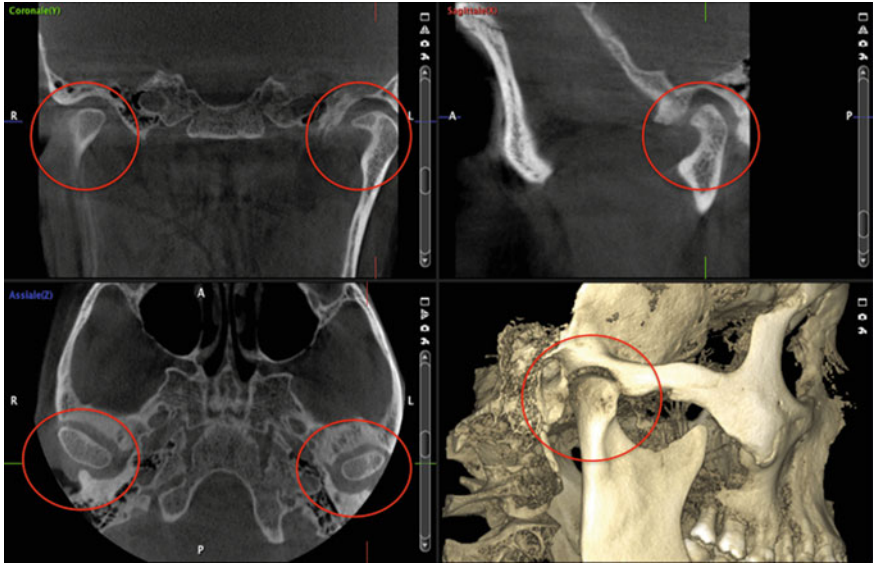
Temporomandibular joint: screenshot of the CBCT software window; it is easy to visualize joint components in the coronal, axial, sagittal planes, and the 3D-reconstruction
